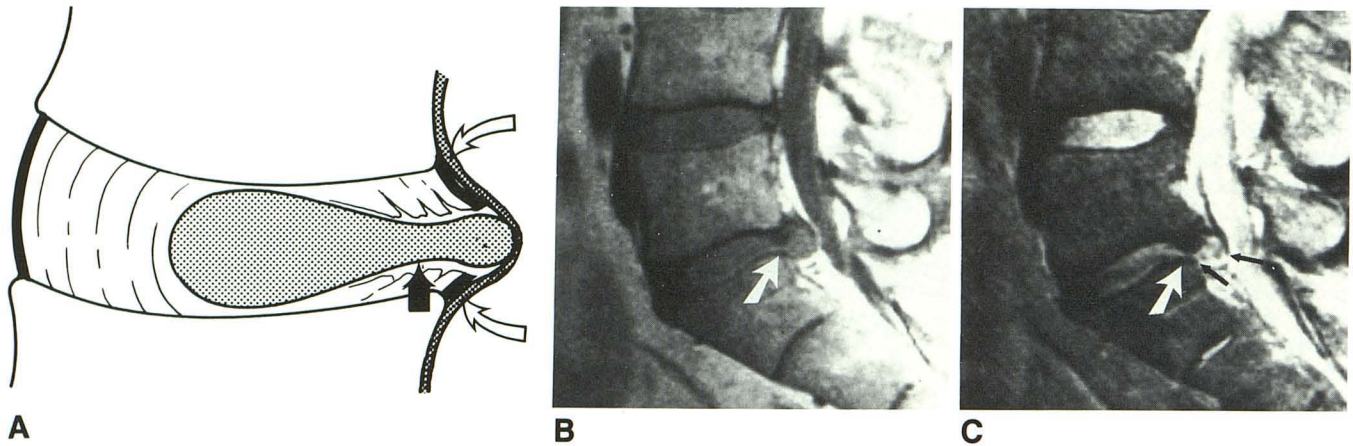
A, Extruded disk is defined as herniation of nuclear material resulting in anterior extradural mass, which remains attached to nucleus of origin via high-signal pedicle on T2-weighted images (*straight arrow*). Lesion is no longer bounded by outer annular fibers (*curved arrows*) and may lie anterior or lateral to posterior longitudinal ligaments. Extradural defects often possess higher signal than (and thus can be distinguished from) adjacent outer annulus.
